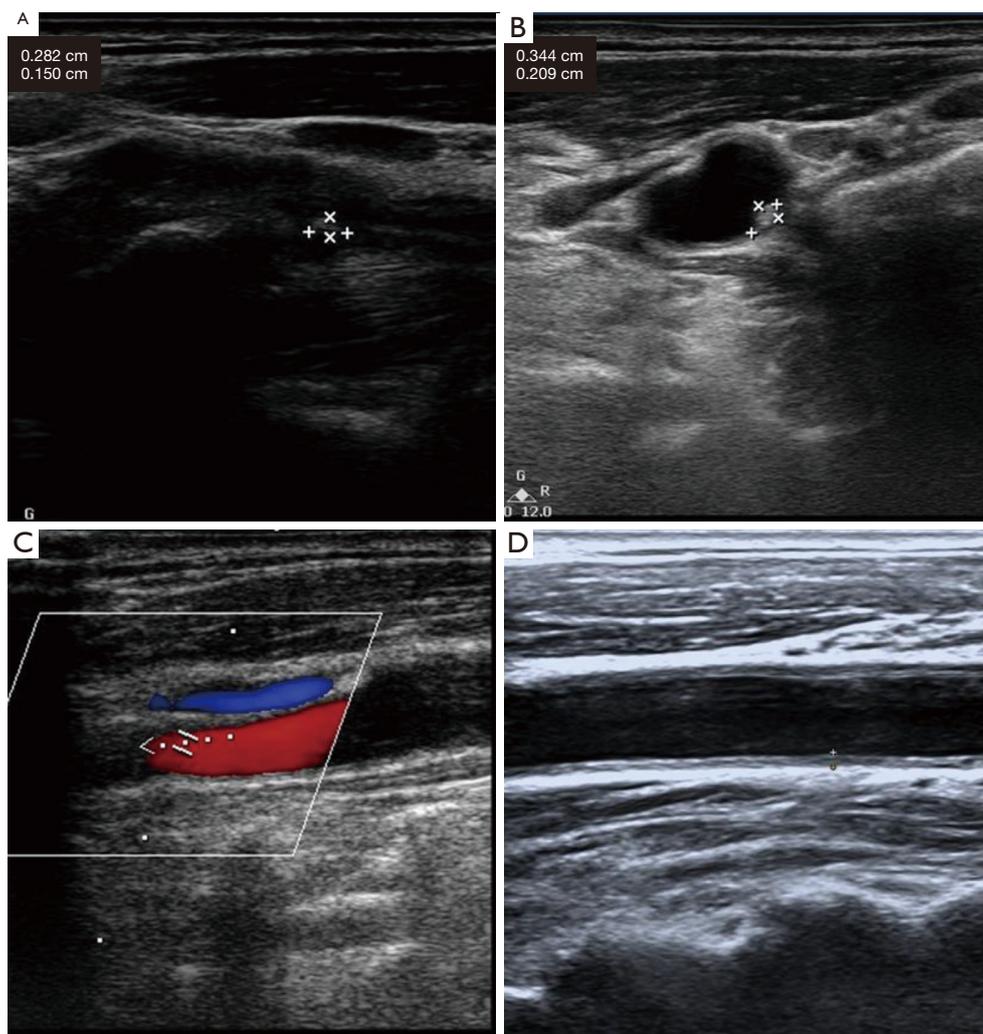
Ultrasound image of CAS during patients follow-up. (A,B) An example of CAS progression; (C,D) an example of CAS regression. CAS, carotid artery stenosis.
